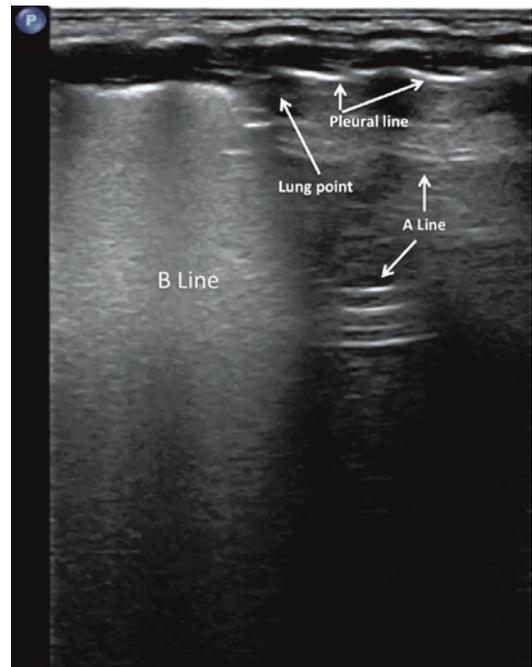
Ultrasonic manifestation of pneumothorax. Ultrasound lung scan in B mode showing the lung point, that is, the transition from the B-line area (*left side*) to a hypochoic area (*right side*). Under real-time ultrasound, lung sliding is occurring in the B-line area, while it is disappearing on the right side of the same picture; the point of demarcation between the consolidation and the right side of the same picture was the lung point (Video 9.5)
